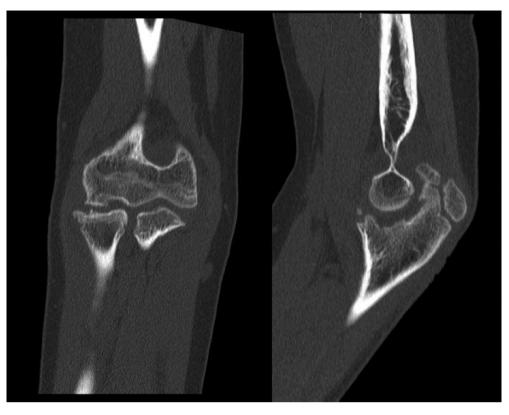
Coronal and sagittal computed tomography scans of left elbow in case 1 showing degenerative changes in ulnohumeral and radiocapitellar elbow compartments.
